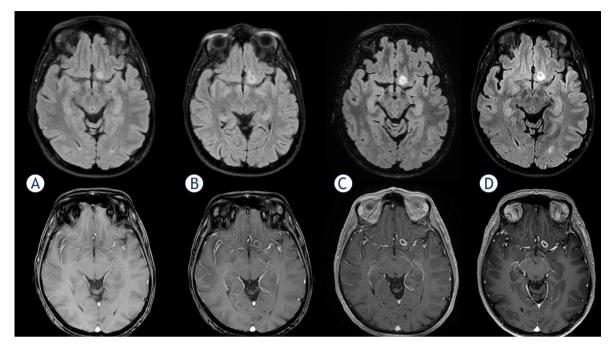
MRI scans in Patient 4 at 0 (A), 160 (B), 196 (C) and 223 (D) days (fluid attenuated inversion recovery [FLAIR] and T1 with gadolinium sequences).
